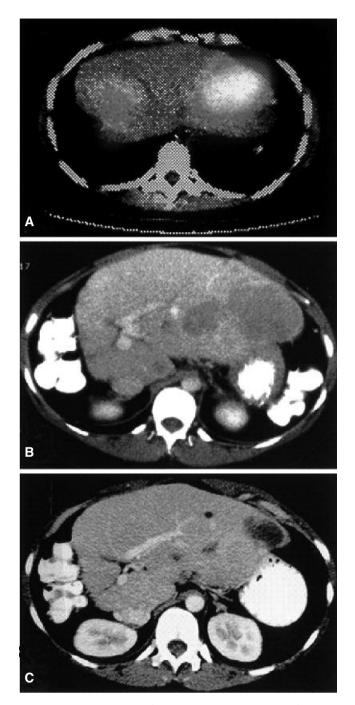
Liver metastases from pancreatic insulinoma before and after ⁹⁰Y-DOTATOC therapy in a 38-year-old patient with good up-take. A) OctreoScan prior to treatment superimposed on CT. B) CT prior to treatment. C) CT 8 months after treatment: a remarkable reduction in liver lesions is evident.
